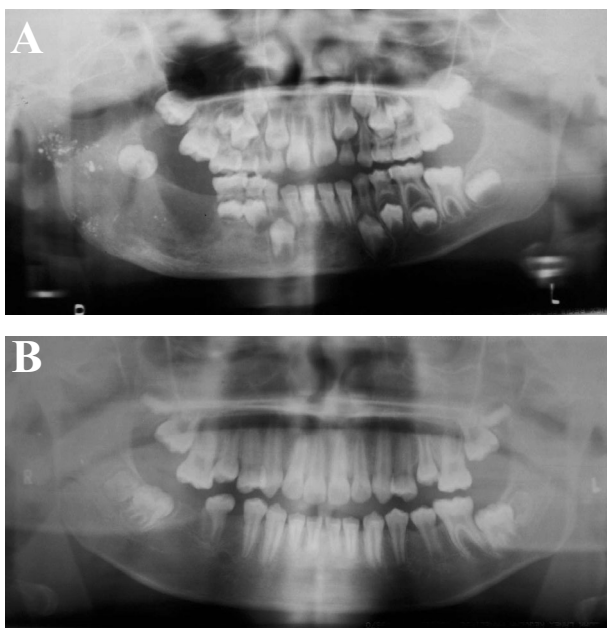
Panoramic radiograph at 4 and a half months after embolization (4A) showing gradual resolution of the vascular lesions as in Figure 2A. Osseous regeneration was observed, but it was still incomplete with the appearance of a radiolucent area. The panoramic radiograph in Figure 4B was taken when the patient was 9 years and 8 months of age, 3 years and 8 months after the embolization. It showed complete osseous regeneration and remodeling of the right side of the mandible.
